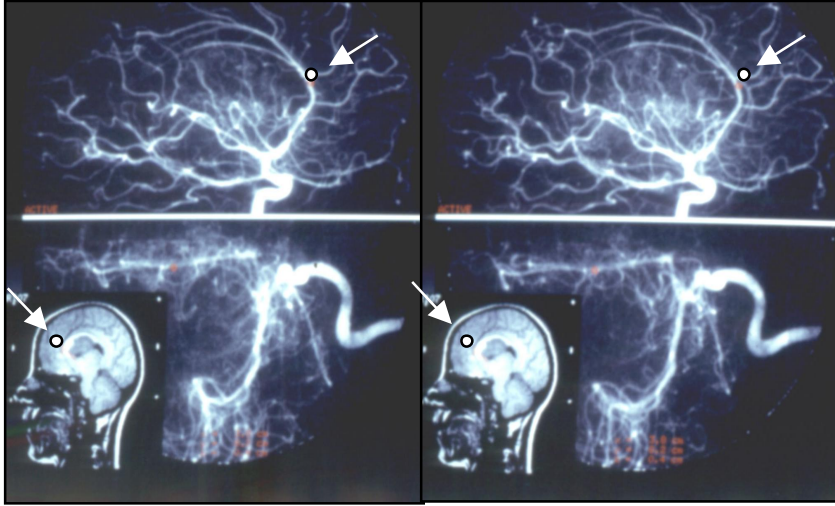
Stereoscopic (crossed-eye) view of lateral (top) and anterior-posterior (bottom) angiograms along with registered MR image. A 3-D cursor (arrows) driven through the volume defined by the angiograms is tracked in the appropriate slice of the MR volume.
